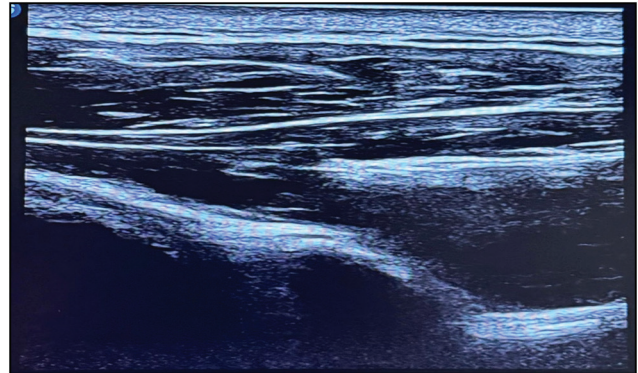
Ultrasound-guided image showing the glenohumeral joint
